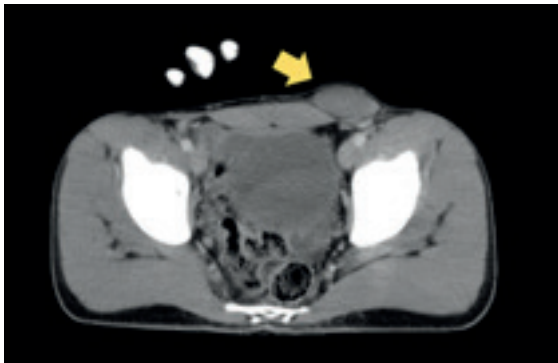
Identified left testis in the left inguinal region on the CT scan (arrow head)
